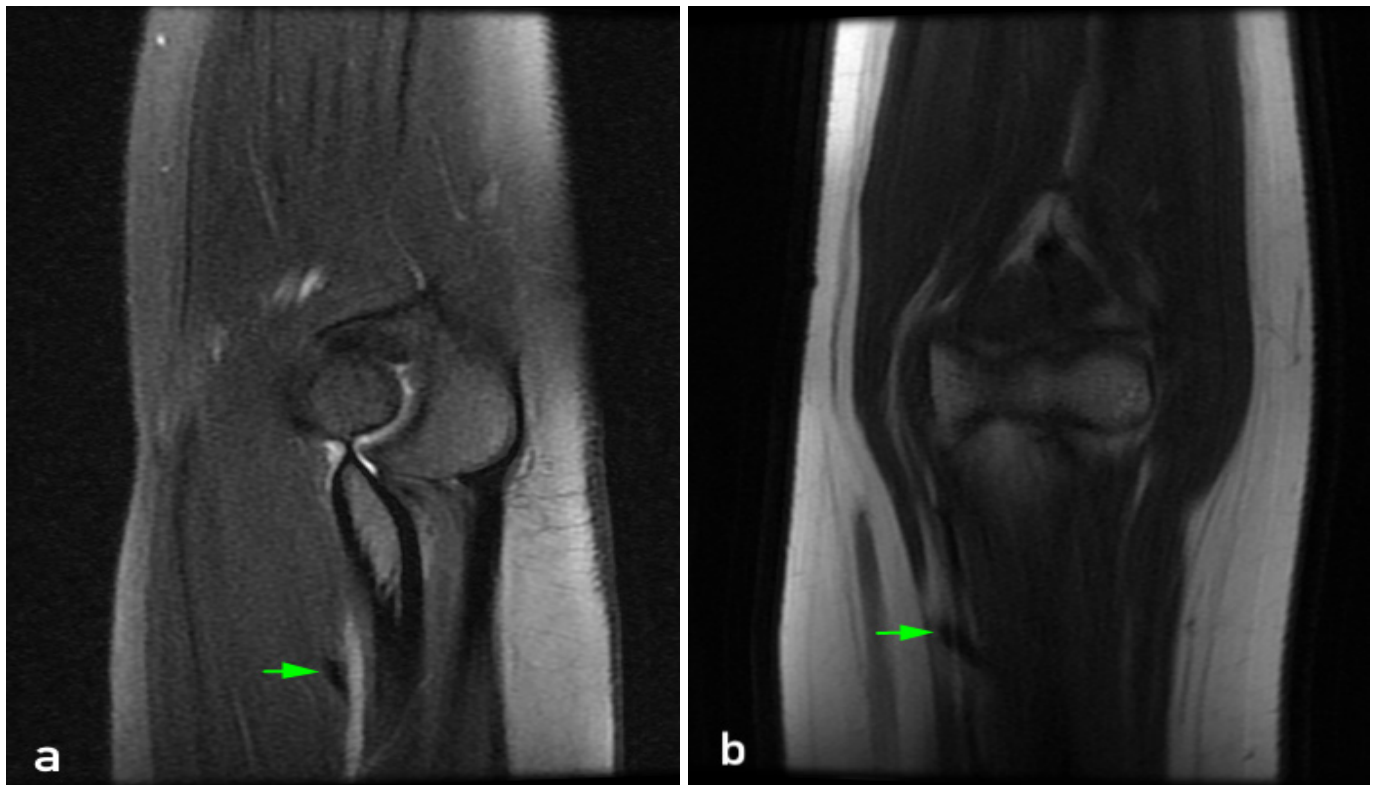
Sagittal T2-weighted (a) and coronal T1-weighted (b) MRI images show a hypointense, slightly oblique transverse structure that is connected to the bony cortex. In contrast to osteochondroma, this structure lacks a medullary bone signal and a cartilage cap (green arrows).
